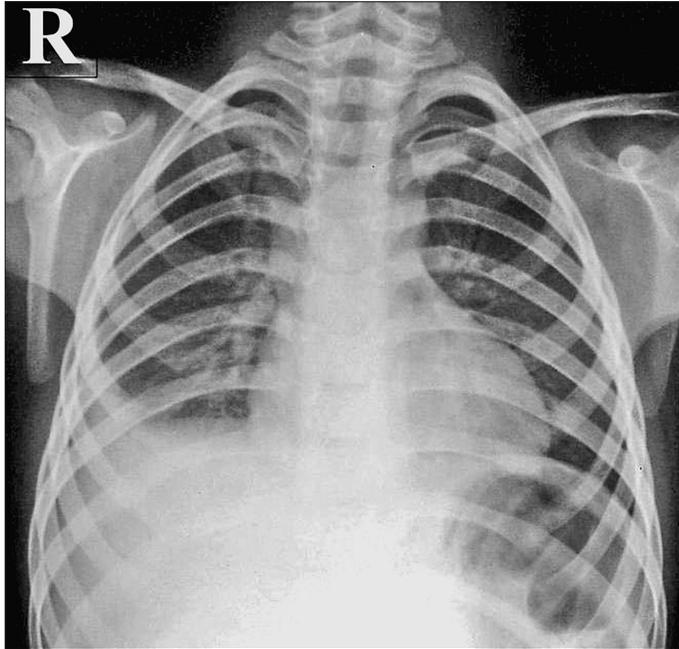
Chest X-ray revealed pleural effusion
